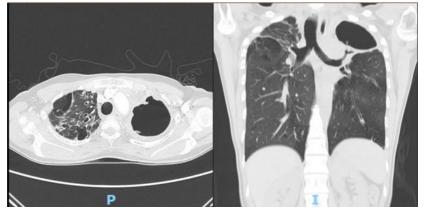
Contrast-enhanced chest CT scan three months after treatment with fluconazole
